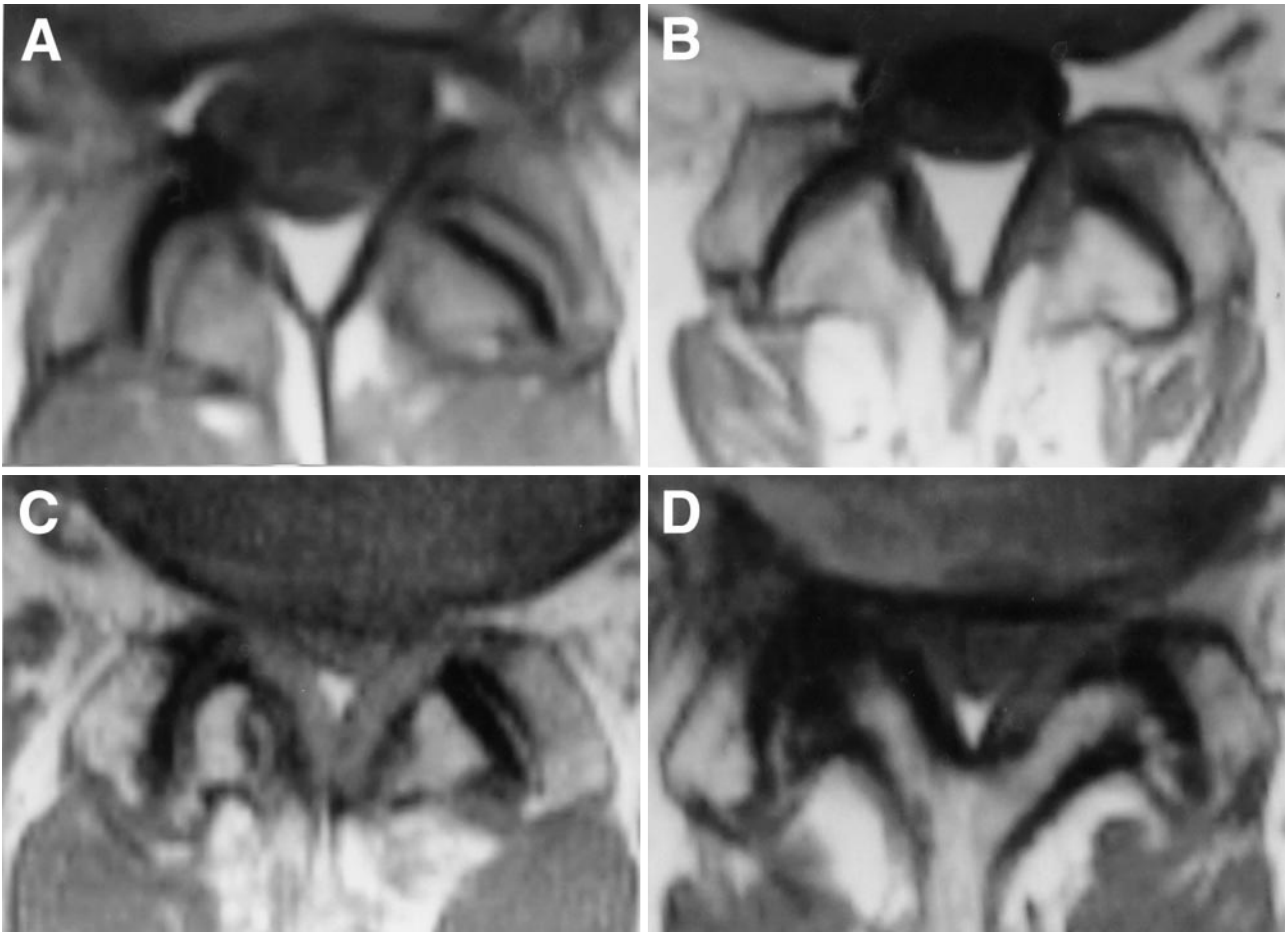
A–D Four grades of facet joint osteoarthritis on MRI (TR = 570 ms/TE = 15 ms, 5 mm thickness). A Grade 1: normal. B Grade 2: joint space narrowing or mild osteophyte. C Grade 3: sclerosis or moderate osteophyte. D Grade 4: marked osteophyte
